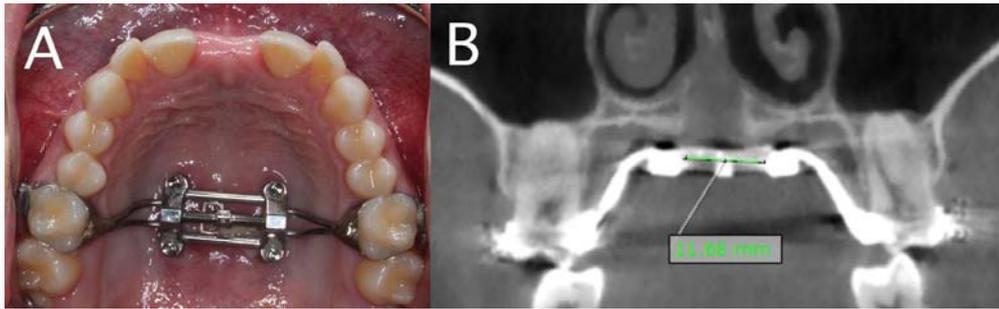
Maxillary skeletal expander: A) intraoral occlusal view; B) CBCT coronal section. The opening of the mid-palatal suture can also be appreciated.
